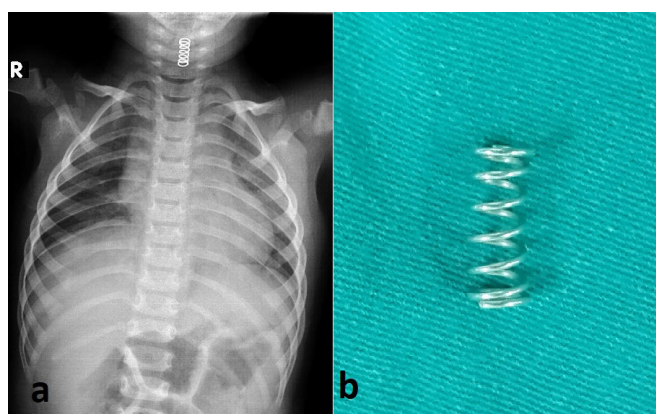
(a) Aspirated latch spring, PA chest x-ray view at the level of vocal cords, (b) Removed latch spring.
